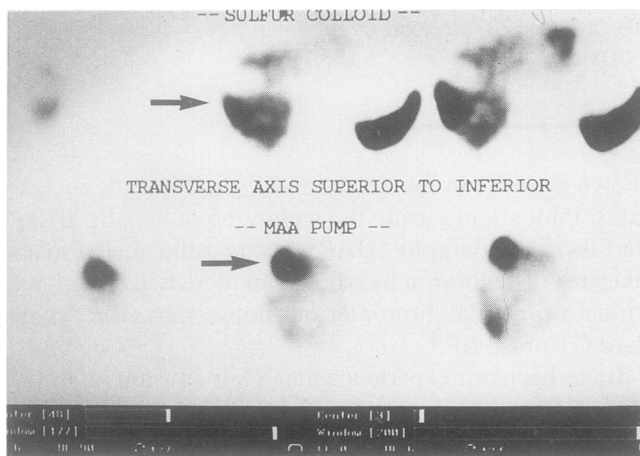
Standard sulfur colloid nuclear medicine scan demonstrates a space occupying metastatic lesion (arrow above). Hepatic artery infusion scintigraphy (MAA) demonstrates positive uptake of macroaggregated albumin into this metastatic lesion (arrow below).
